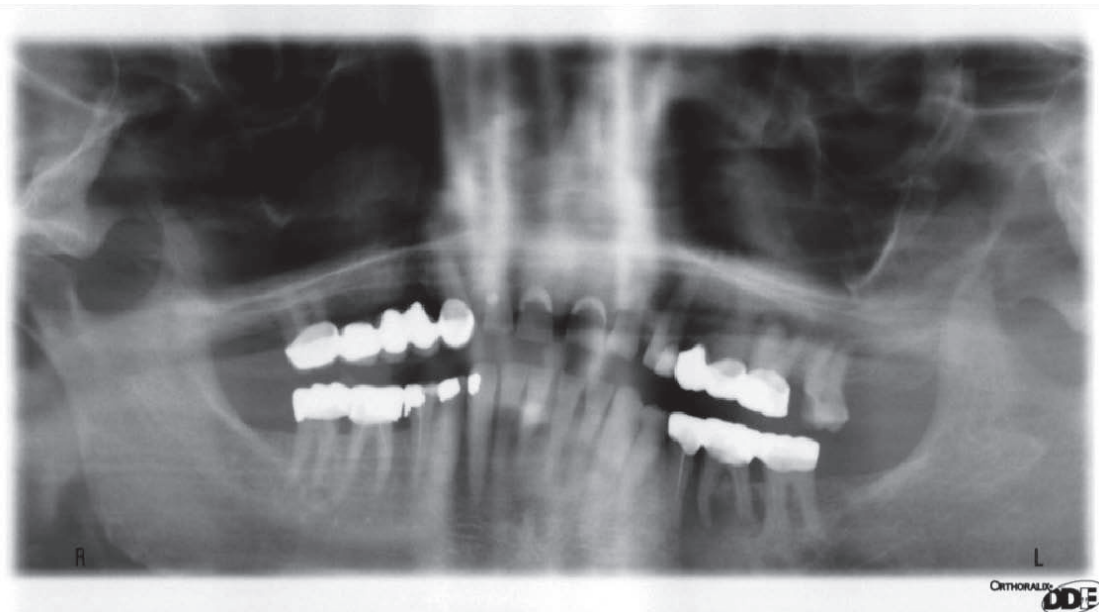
Oral Panoramic radiograph.
